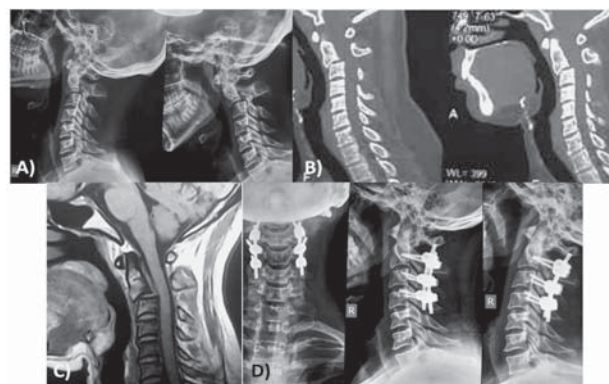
Radiological images, A) preoperative dynamic X-Ray of cervical spine showing hangman fracture of C2-3, B) CT scan of cervical spine, C) T1W MRI of cervical spine, D) post-operative X-Ray of cervical spine
